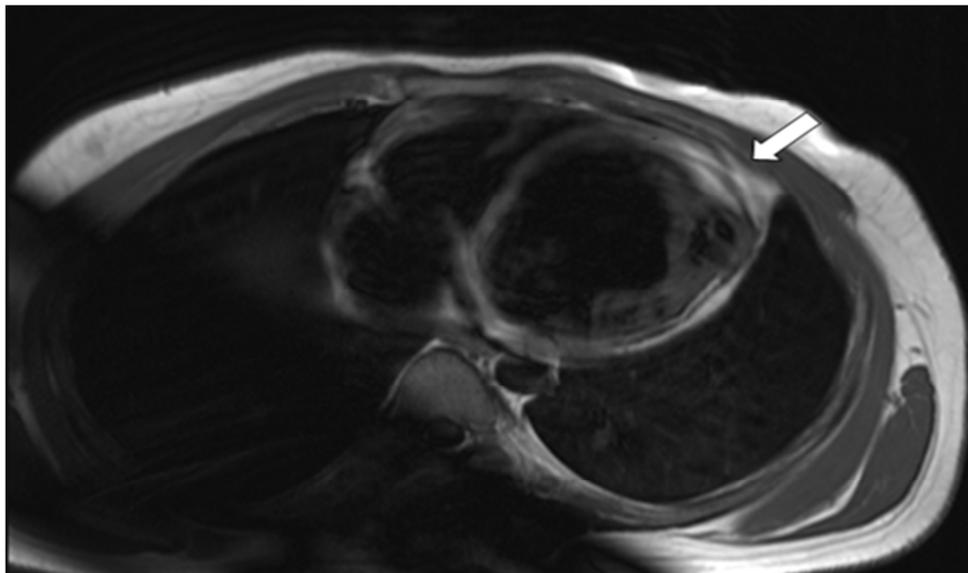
A T1-weighted image shows bright tissue replaced in the left ventricle (LV) apical position (white arrow), which could suggest the presence of fat replacement
